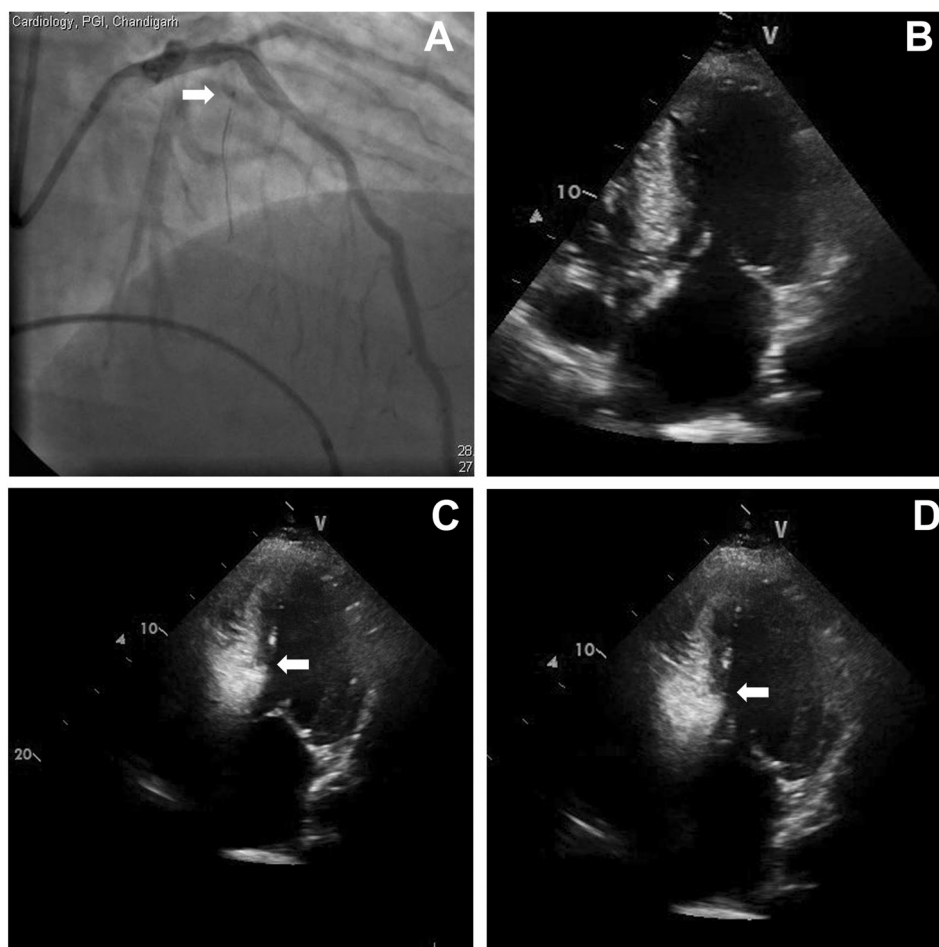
(A) Coronary guidewire and central marker of over the wire balloon (arrow) seen in the first septal branch that was ablated. (B) Apical four chamber view showing the interventricular septum prior to injection of agitated gelatin. (C and D) Apical four chamber view following injection of agitated gelatin through the central lumen of the coronary balloon. Bright gelatin depot in the basal interventricular septum is clearly seen (arrows). The depot extends across the septal-mitral contact point.
